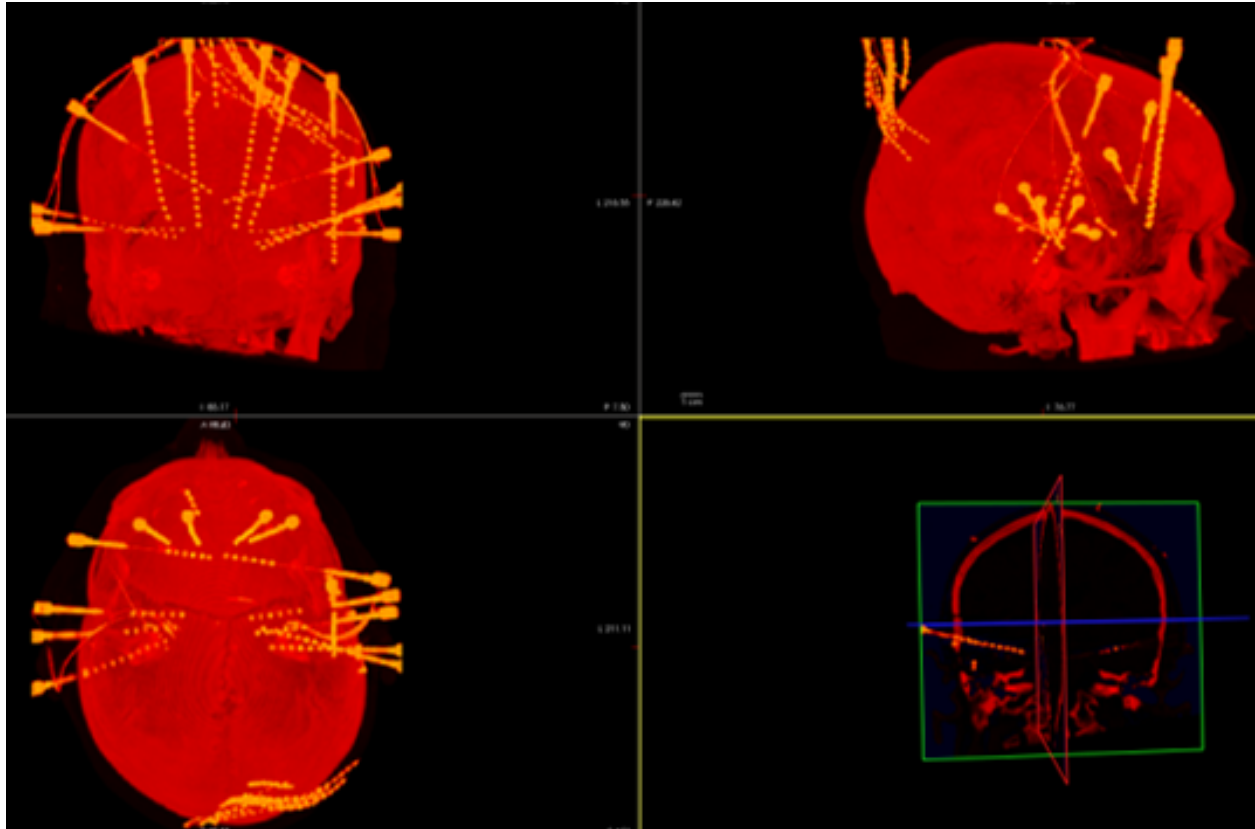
Post-operative CT
